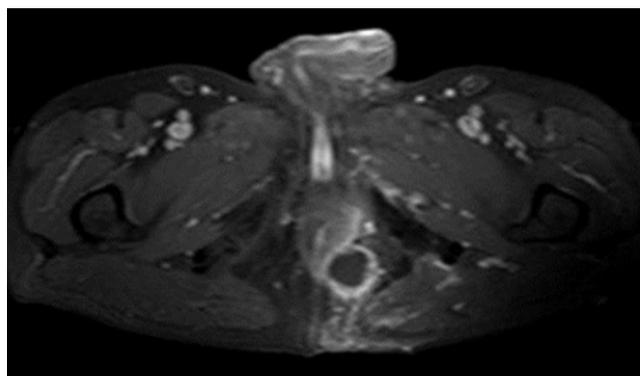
Axial post-contrast fat-saturated T1W MR image shows peripherally contrast-enhancing ischioanal fossa abscess with external sphincter inflammation on the left side.
